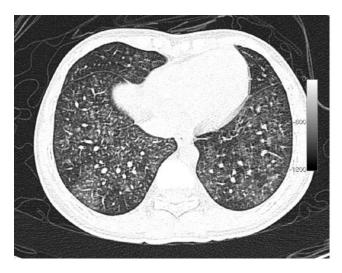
HRCT appearance of lupus pneumonitis¹³
